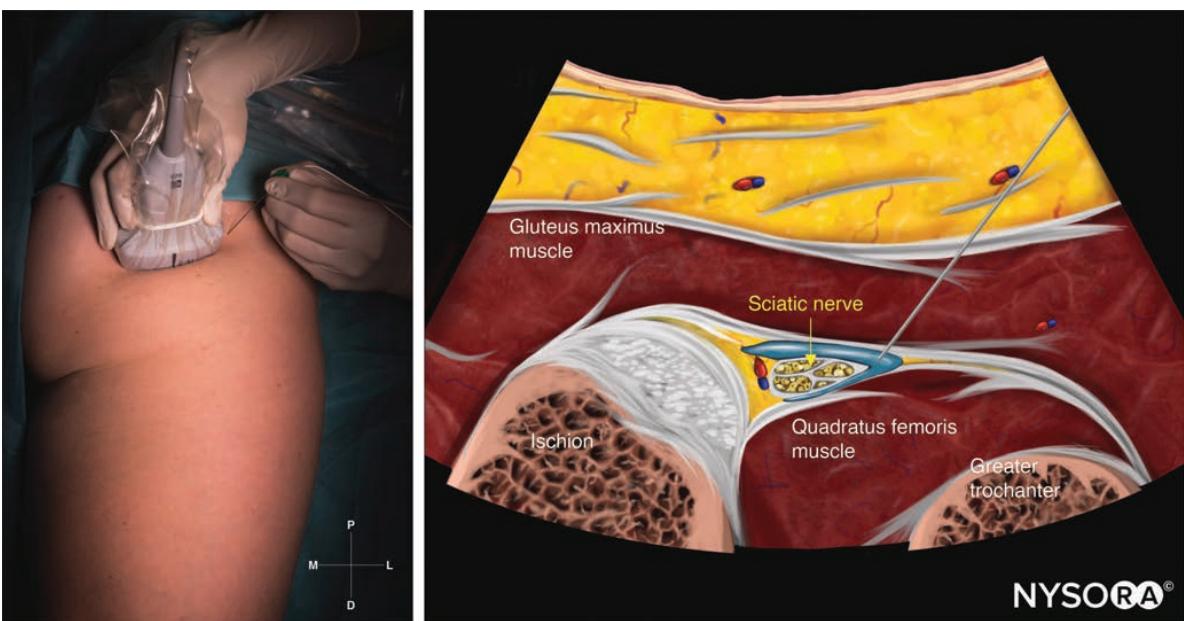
Reverse ultrasound anatomy of a proximal sciatic nerve block at the gluteal level with needle insertion in-plane.
